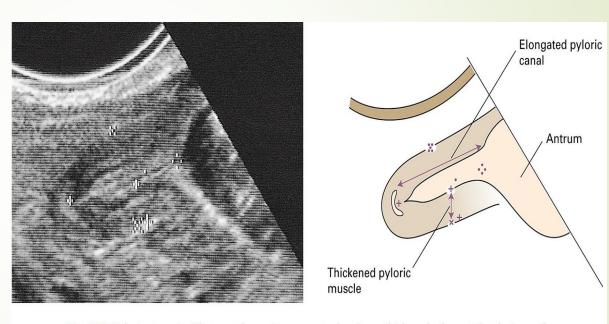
Pyloric stenosis. Ultrasound scan in a neonate showing a thickened, elongated pyloric canal.
